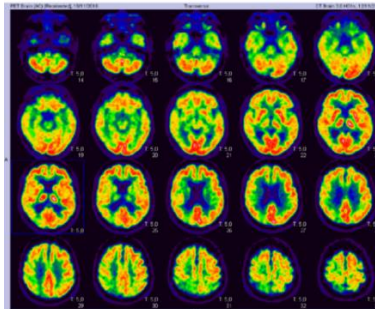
Patient A: cerebral FDG-PET showing a significant hypometabolism in the posterior temporal and occipital cortex and in the bilateral parietal cortex.
